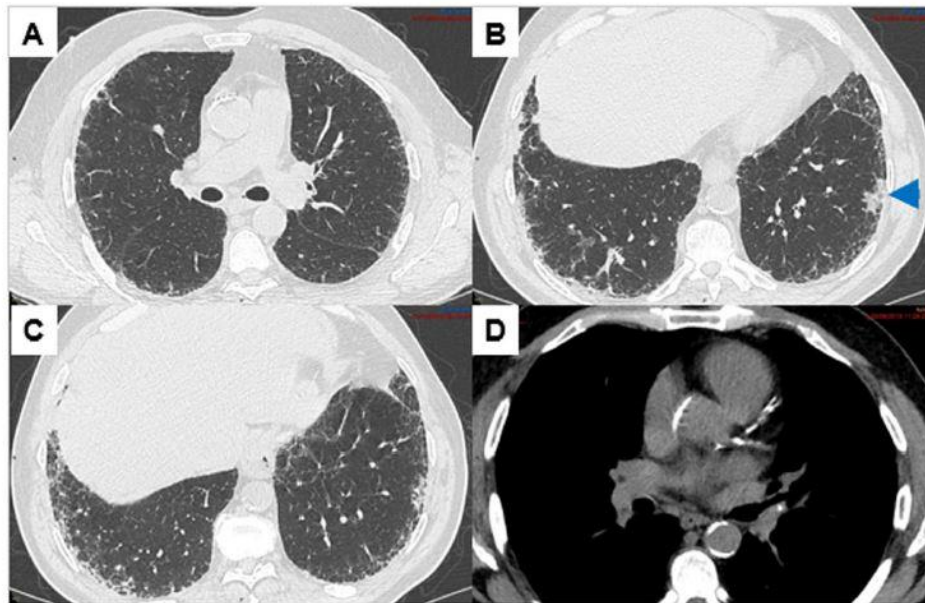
Chest CT scan showing a lung carcinoma in a patient with idiopathic pulmonary fibrosis. A–C: probable usual interstitial pneumonia pattern (parenchymal window). B: subpleural nodule of the lower left lobe corresponding to a carcinoma (arrowhead). D: coronary calcifications (mediastinal window).
